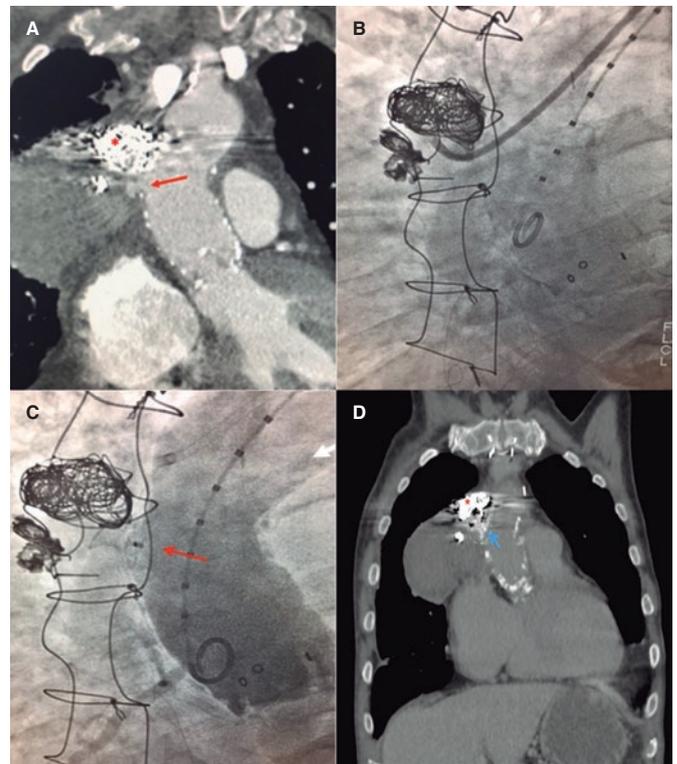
A: Coronary computed tomography angiography after coil release (asterisk) with presence of contrast in the cavity of the pseudoaneurysm indicative of incomplete occlusion. The entry neck (arrow) and larger size compared to the initial study can be seen. B: fluoroscopic imaging showing the distal border of the 8-Fr JR4 delivery catheter inserted into the pseudoaneurysm. C: post-implantation aortography. Occluder device (arrow) delivered inside the neck of the pseudoaneurysm. No significant passage of contrast to the inside is seen. D: thoracic computed tomography scan without contrast performed after 4 weeks. Occluder device (arrow) on the lateral wall of the aorta and coil metal artifact (asterisk) implanted in the main cavity of the pseudoaneurysm.
